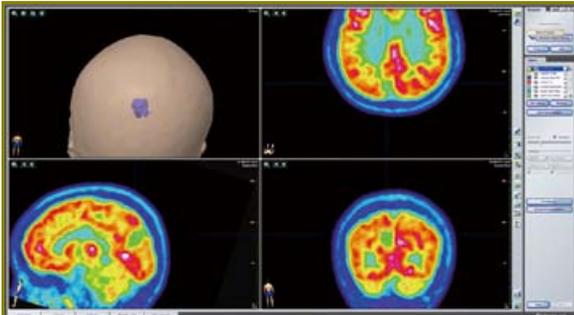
Inter-ictal FDG PET showed area of hypometabolism in left cuneus in Brain Navigation system. Patient became seizure-free after resective surgery. Pathology showed focal cortical dysplasia IIB.
